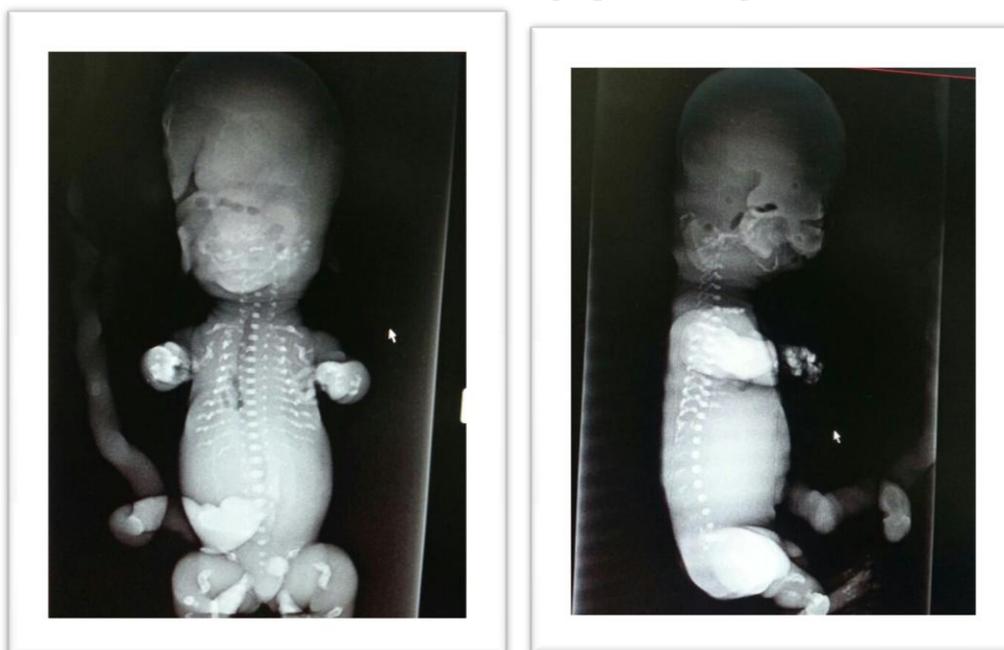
Post mortem radiographic findings showing relatively large head ,shortened Limbs ,telephone handle femur appearance ,small thoracic cage, small horizontal ribs ,small scapula and hypoplastic iliac bone,frontal bossing and flattened vertebral bodies.
